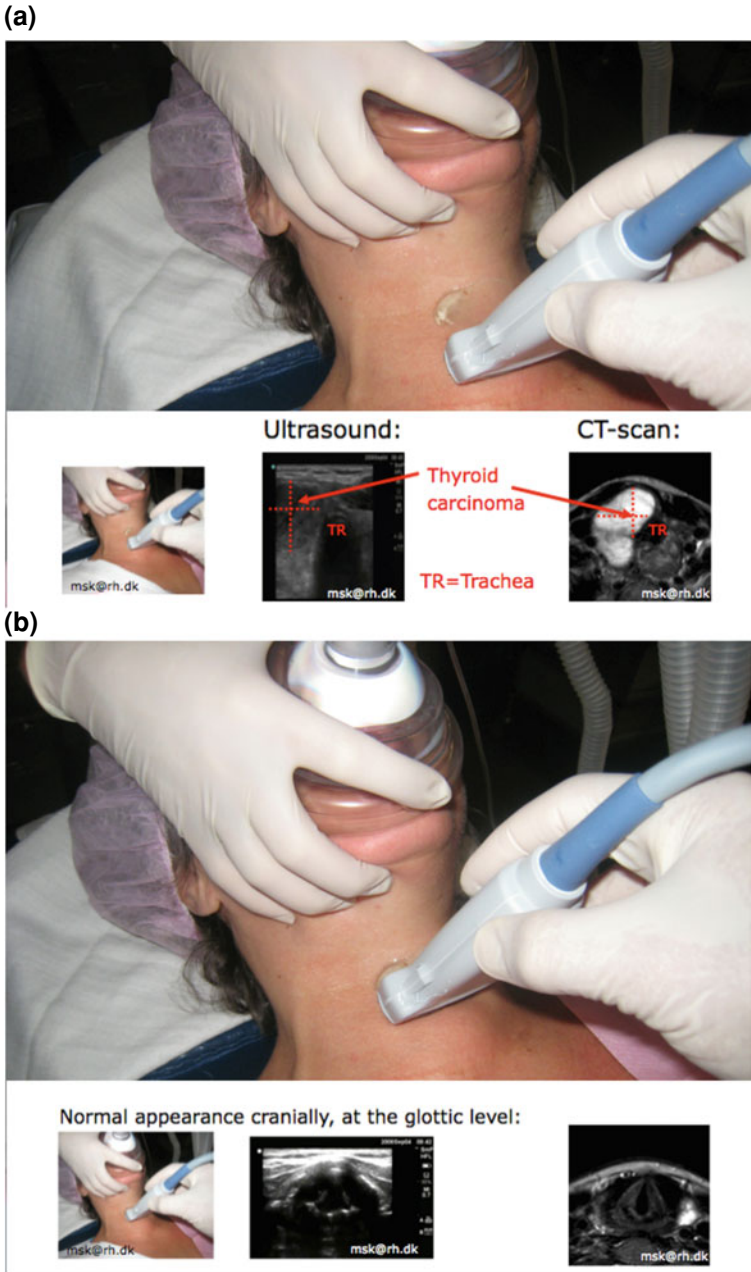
a A mass on the neck. The ultrasound scanning at the level of the thyroid gland reveals a thyroid tumour and gives the same information as the ct-scan. b A mass on the neck, continued. The ultrasound probe is place more cranial than in Fig. 9a and reveals a glottic opening in the midline, without pathology (Courtesy The Scandinavian Airway Management Course, Airwaymanagement.dk)
